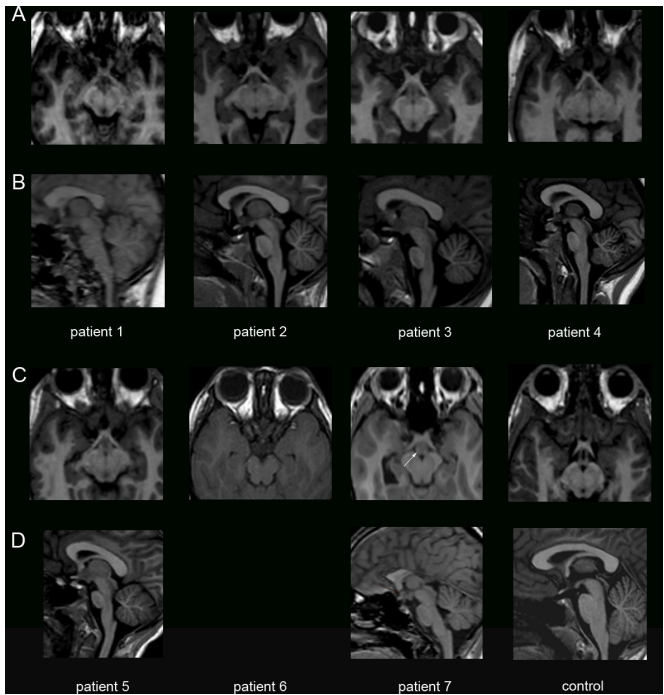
Developmental hypothalamic defects in patients with *CDK5RAP2* variants. Coronal (A, C) and sagittal (B, D) T1-weighted images showing in patients 1, 2, 4, 5 and 7 a structure iso-intense to grey matter consistent with an interhypothalamic adhesion (IHA, white arrows), and absent in the healthy control. This grey matter band on coronal view and nodular on sagittal view is located at the level of the upper midbrain, closed to the anterior/inferior third ventricle. IHA is known to connect both dorsomedial and ventromedial hypothalamic nuclei and/or arcuate, paraventricular or pre-optic nuclei on both sides of the third ventricle.
